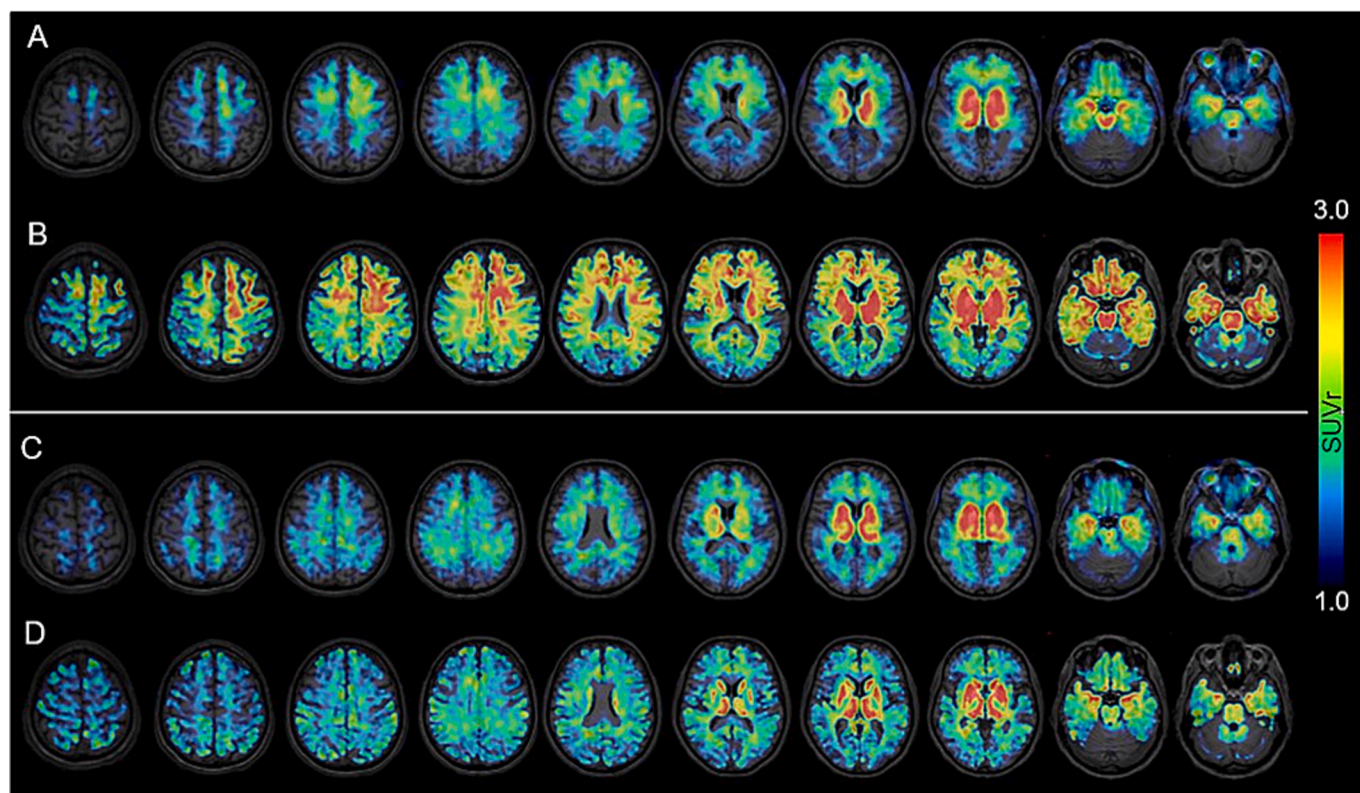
Exemplary images of one nfv-PPA patient without/with PVEC (A, B) compared to one HC without/with PVEC (C, D). nfv-PPA = non-fluent/agrammatic primary progressive aphasia; HC = healthy control; SUVr = standard uptake value ratio, PVEC = partial volume effect correction.
